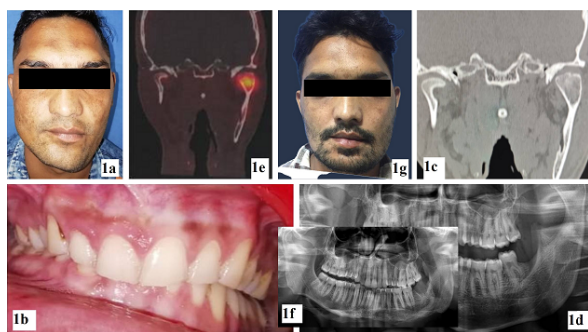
g): a) Depicts asymmetrical with vertically elongated left facial side, and deviation of the chin towards the right side, along with bowing of left lower border of the mandible; b) Evident deep bite with open bite wrt left side, along with occlusal cant downwards towards the left side; c-d) Orthopantomogram and computed tomography (CT) of the face showed osseous outgrowth of the left mandibular condyle antero-medially, along with vertically elongated left mandible; e) Tc-99m MDP bone scintigraphy shows increased osteoblastic activity with respect to left condylar head; f) Post-operative OPG shows left TMJ condylectomy along with shaving of lower border of mandible; g) Follow up picture depicting swing-back of the mandible to left side, leading to the correction of facial symmetry and dental midline.
